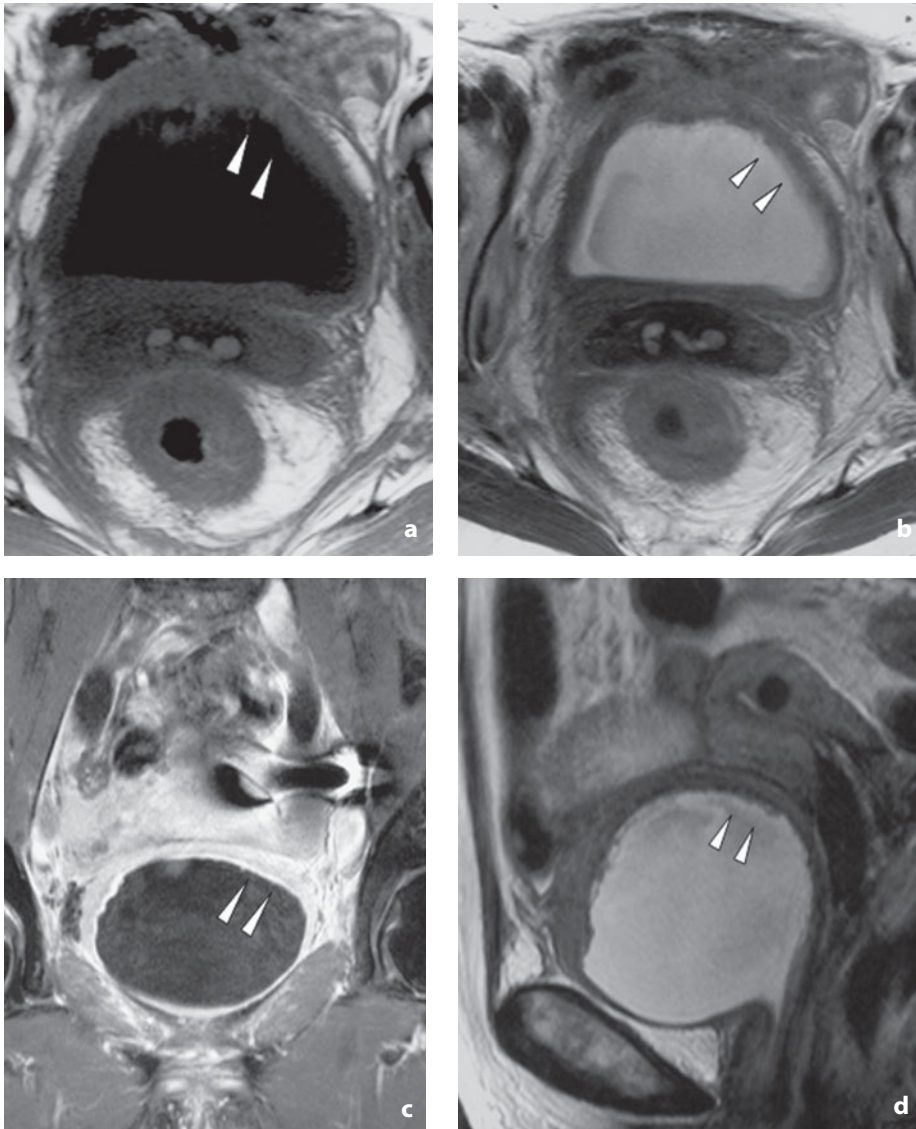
Magnetic resonance. Bladder cancer, stage T1. T1-weighted (a) and T2-weighted (b) images show slight eccentric thickening of the bladder wall (*arrowheads*). The finding is confirmed in the coronal T1-weighted (c) and sagittal T2-weighted (d) images
